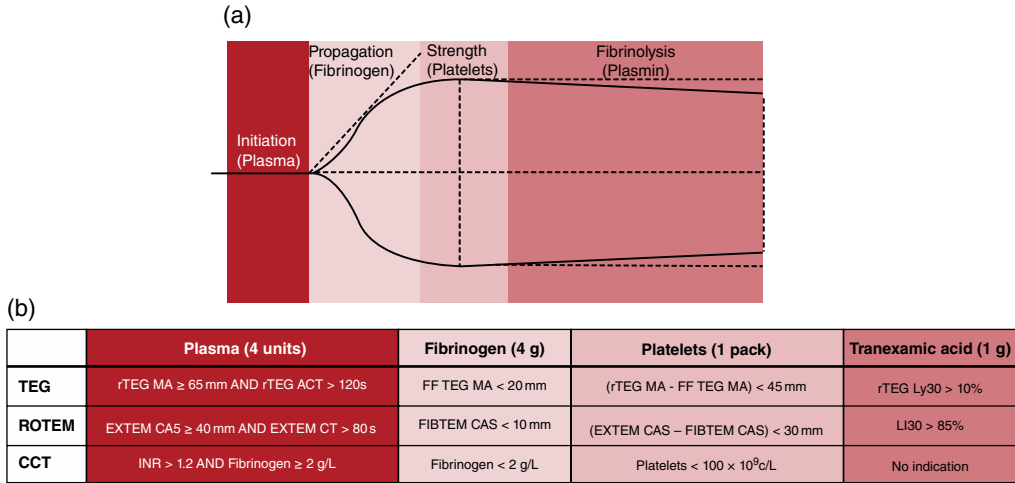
Data-driven thresholds for component resuscitation in trauma resuscitation. (a) A colour-coded viscoelastic monitoring (VEM) tracing is depicted with the four phases of clot dynamics measured by thromboelastography (TEG) and rotational thromboelastometry (ROTEM), accompanied by the primary biological component responsible for the measured activity. (b) The table outlines thresholds for additional component resuscitation based on VEM and CCT, adapted from Baksaas-Aasen et al. [7]. The quantity of additional component to be administered is shown in parentheses. ACT, activated clotting time; CA5, clot amplitude at 5 minutes; CT, clotting time; EXTEM, extrinsic rotational thromboelastometry; FF TEG, Functional Fibrinogen thromboelastography; FIBTEM, fibrin-based rotational thromboelastometry; INR, international normalised ratio; LI30, unlysed fraction at 30 minutes; Ly30, lysis fraction at 30 minutes; MA, maximum amplitude; rTEG, rapid thromboelastography. *Source:* Sayce AC, Neal MD, Leeper CM. Viscoelastic monitoring in trauma resuscitation. *Transfusion* 2020;60(Suppl 6):S33–51. Reproduced with permission of John Wiley & Sons.
